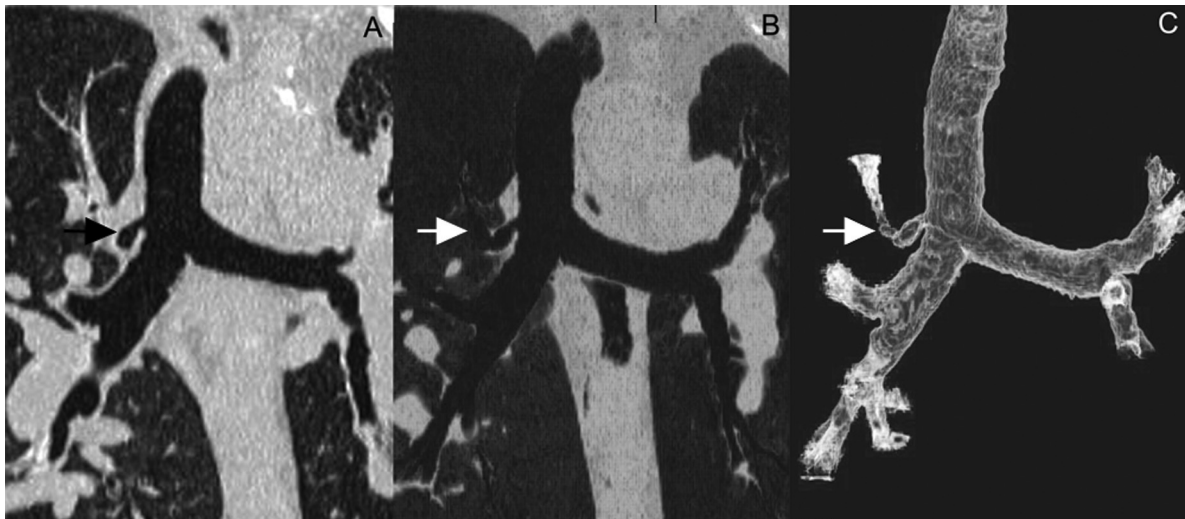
High resolution MDCT images showing tracheal bronchus (bronchus suis; arrowheads), to the right upper lobe originating from the right side of trachea. (A) Coronal reconstruction in lung windows. (B) Coronal MinIP reconstruction. (C) 3D volume rendering reconstruction. MDCT: multi-detector computed tomography; MinIP: minimal intensity projection. 3D: 3-dimensional.
